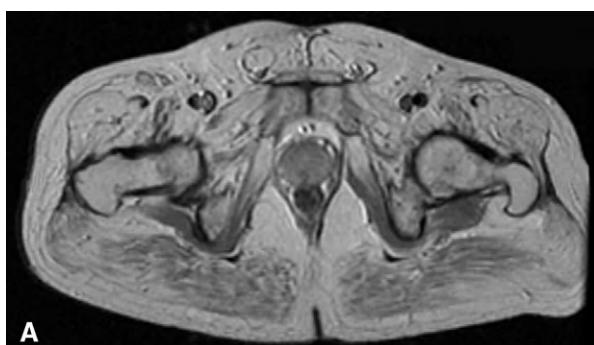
Skeletal muscle magnetic resonance imaging (MRI). (A) Skeletal muscle MRI scan (T_1 -weighted/proton density) through the pelvis demonstrates relative preservation of the gluteus muscles at this level. (B) Scan through the thigh reveals severe fatty infiltration of all the muscles in the thigh, worse in the posterior compartment.
